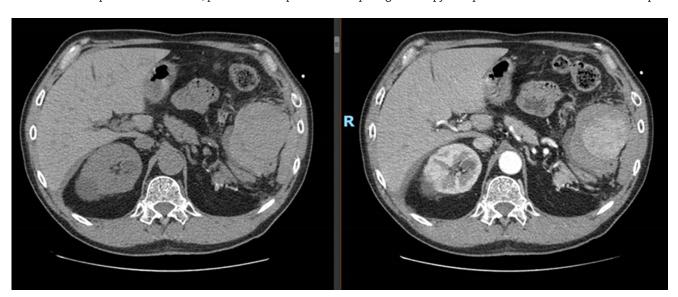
Abdomen CT without and with contrast medium showing hypertrophic accessory spleen with an axial diameter of 55 mm with peripheral collection sparing the hilum region identifiable in the posterolateral area. That collection is more relevant on the upper pole, it is spontaneously hyperdense and supplied by an arterial spot from active bleeding on the antero-superior face of the organ. Moreover, an intraperitoneal hemorrhagic diffusion in the perisplenic adipose tissue was evident, which collects in the right perihepatic recesses, in Morrison's space, in the right parieto-colic shower, and in the pelvis.
